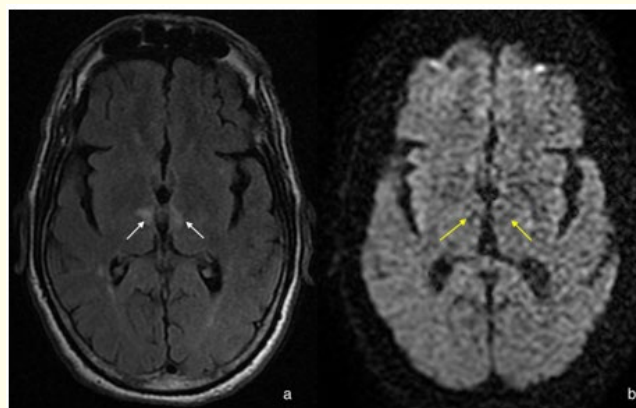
Patient 2: Brain MRI in axial section in FLAIR sequence (a) and diffusion (b) shows high signal intensity in bilateral paramedian thalamic in FLAIR sequences (white arrow) that show no restriction in diffusion (yellow arrow).
